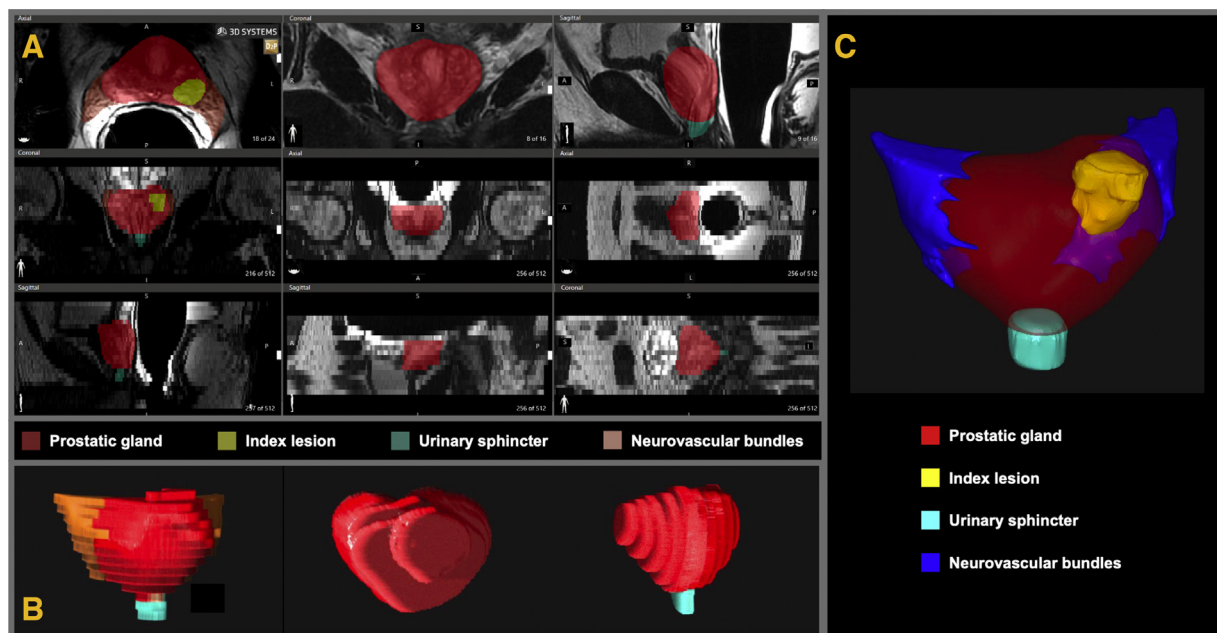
Example of process to obtain the 3D virtual anatomical model (A) starting from patient mpMRI, (B) by the segmentation of the anatomical regions of interest (prostatic gland, index lesion, urinary sphincter, and neurovascular bundles) to (C) the final 3D model. 3D = three dimensional; mpMRI = multiparametric magnetic resonance imaging.
